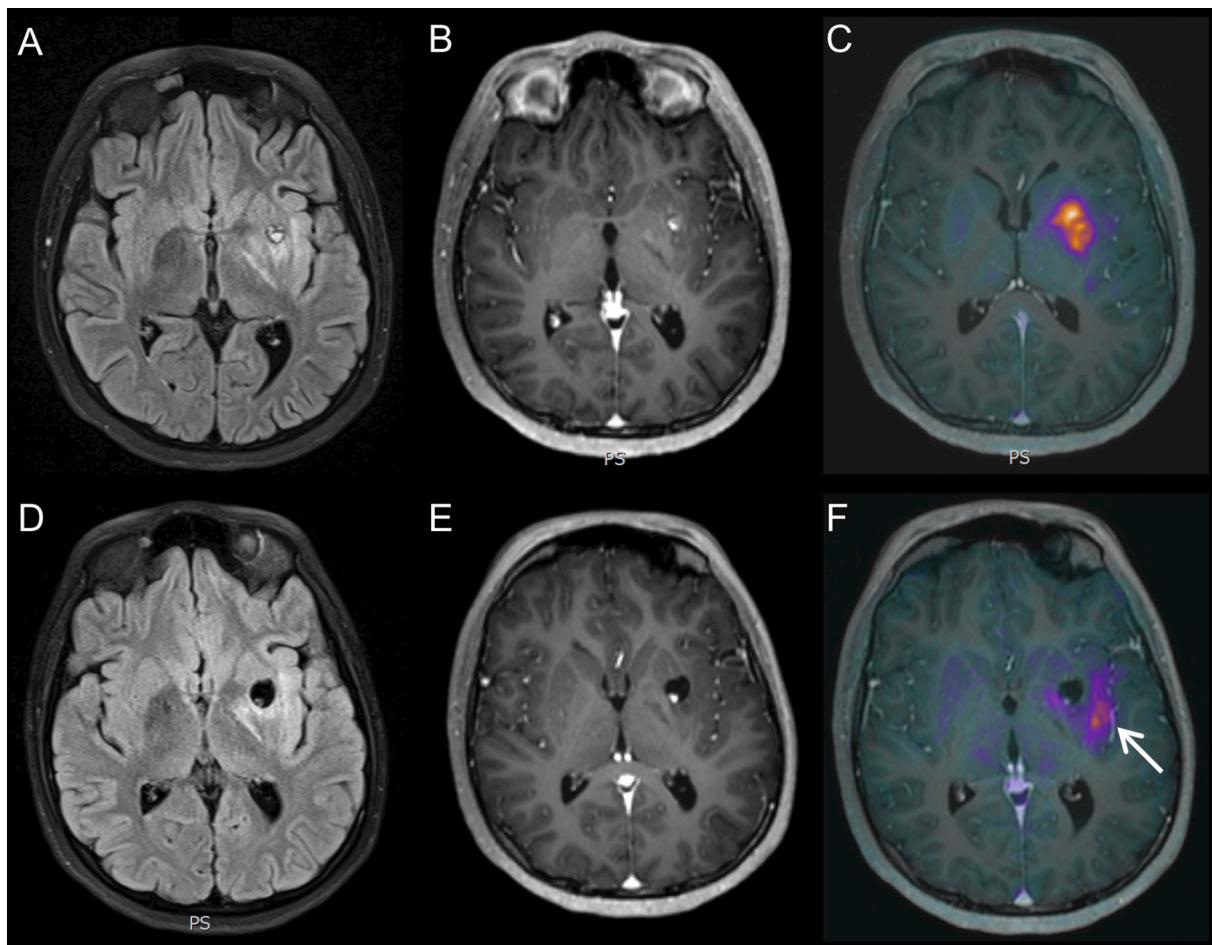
13-year-old female with a diffuse anaplastic astrocytoma of the left basal ganglia. MRI performed 1 month after initiation of radiotherapy. (A) Axial FLAIR, (B) axial T₁-weighted (T₁W) after injection of a gadolinium-based contrast agent (GBCA) and (C) axial fused [¹⁸F]DOPA /T₁W post GBCA. FLAIR signal changes centered in the left thalamic region. The nodular bright spot represents post biopsy hemorrhage with no enhancement. [¹⁸F]DOPA-PET shows intense uptake centered at the level of the thalamic region. Follow up MRI at 8 months: (D) axial FLAIR, (E) axial T₁W post GBCA and (F) axial fused [¹⁸F]DOPA/T₁W post GBCA. A similar FLAIR signal abnormality is seen with the expected evolution of the previous hemorrhagic changes without contrast enhancement. The [¹⁸F]DOPA-PET demonstrated response at the original tumor site with new spread of disease along the lateral border (white arrow).
